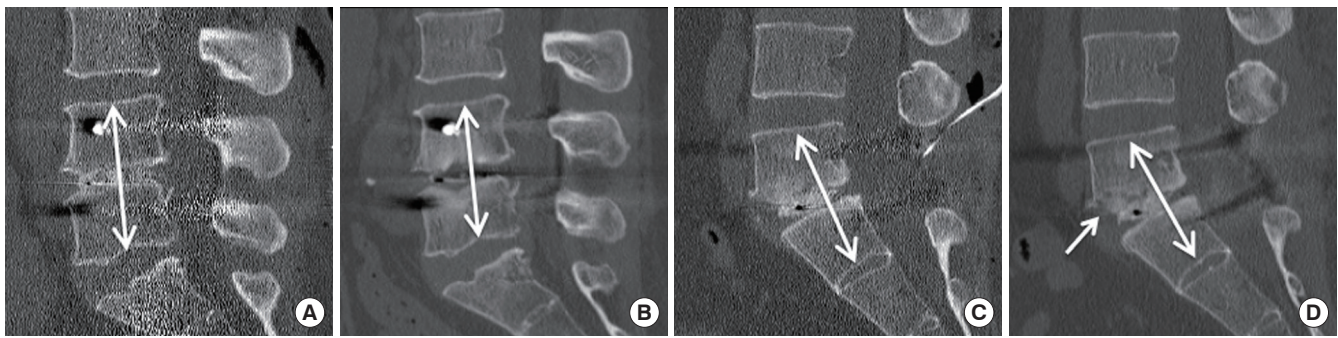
Methods for radiological assessment using computed tomography (CT) scans taken at day 0 (A, C) and 6-month (B, D) postoperation. Vertebral endplate cyst formation was defined as enlargement of the pre-existing cyst or *de novo* formation of a cyst with a diameter greater than 2 mm (D, arrow) on any section of the multiplanar reconstruction sagittal and coronal images. Cage subsidence was referred to as a decrease in the mean distance between the midpoints on the endplates opposite to the side of fusion between day 0 and 6-month postsurgery (A and B, double-headed arrow). The distance was measured using the midline section. In the case of L5–S1 fusion, one of the midpoints was used as the upper end of the S1–2 boundary (C and D, double-headed arrow).
